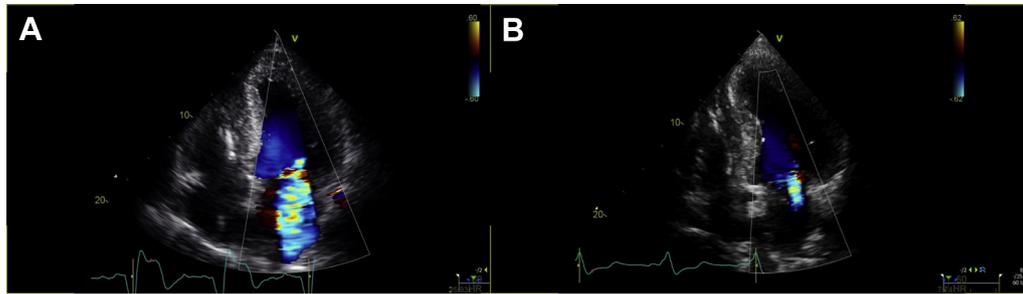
Transthoracic echocardiogram with colour-flow Doppler imaging demonstrating (A) severe mitral valve regurgitation accompanying presentation with acute decompensated heart failure after initiation of amiodarone therapy in a patient with Anderson-Fabry disease and (B) improvement of mitral valve regurgitation to only mild on follow-up examination with resolution of heart failure symptoms after amiodarone was discontinued.
